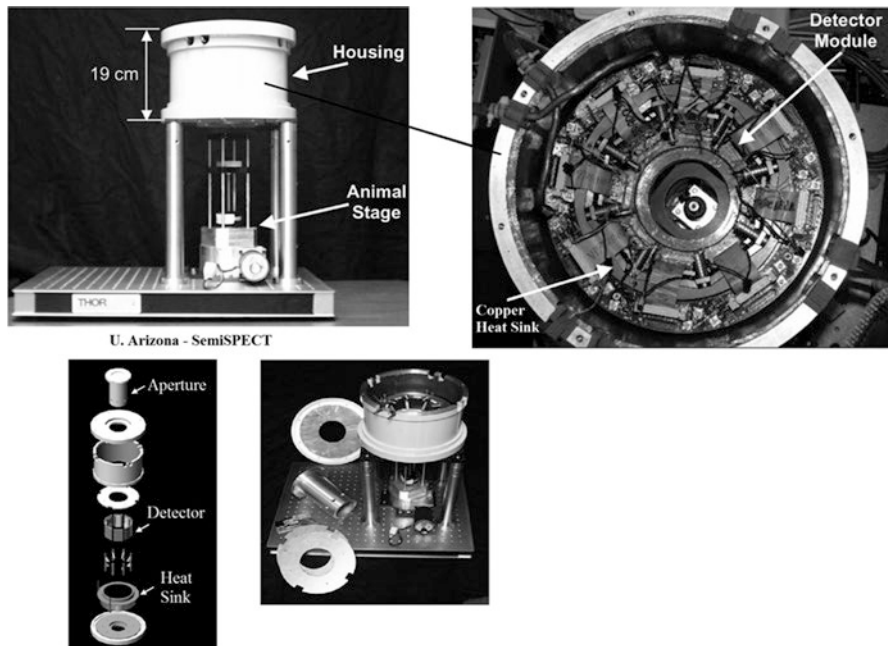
Views of the dual modality SPECT/CT system developed by the Center for Gamma-Ray Imaging at the University of Arizona [60], based on a CdZnTe hybrid pixel detector. The detector head (*rightmost image*) is also used for spot imaging
